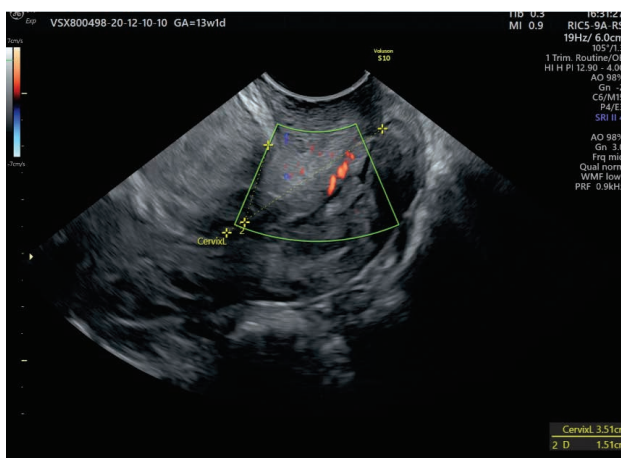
Transvaginal two-dimensional ultrasound image of the cervical canal, containing a hyperechoic protrusive lesion. The color Doppler window looks for pedicle artery and its origin (personal collection of Roxana Bohîlțea)
